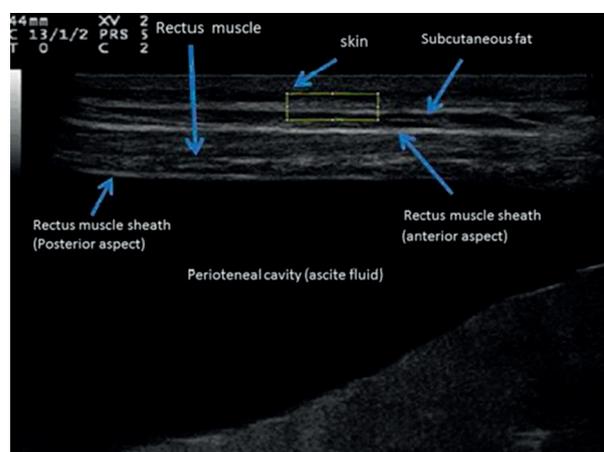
Ultrasound anatomy of the subcutaneous tissue and contiguous structures measured with gray-scale histogram.
